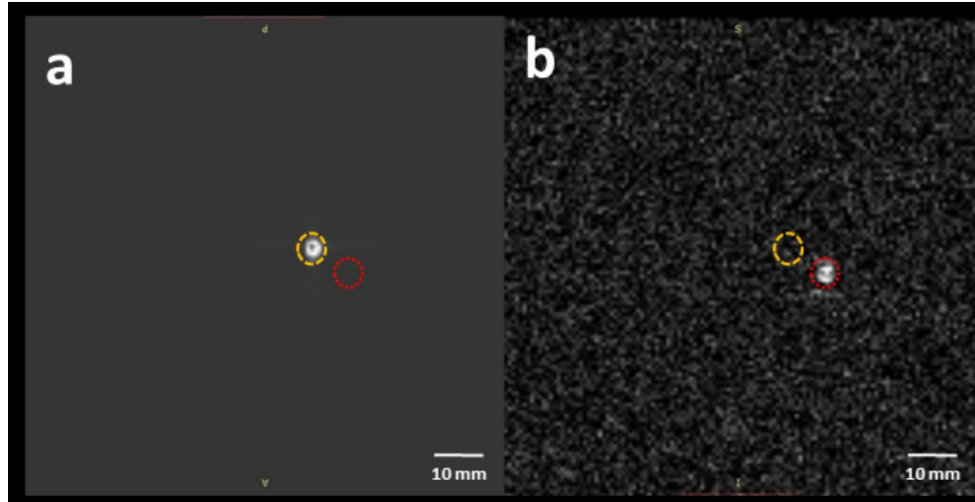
MR image of (a) conventional marker, (b) acousto-optic marker using a GRE sequence and the device receiver channel only. Locations of acousto-optic marker and conventional cable connected marker are highlighted with red and yellow circles respectively.
